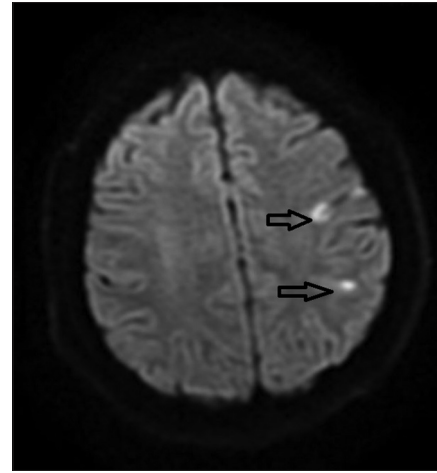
Magnetic resonance imaging of the brain showing acute infarction in Broca's area and post-central gyrus (indicated by arrows)
